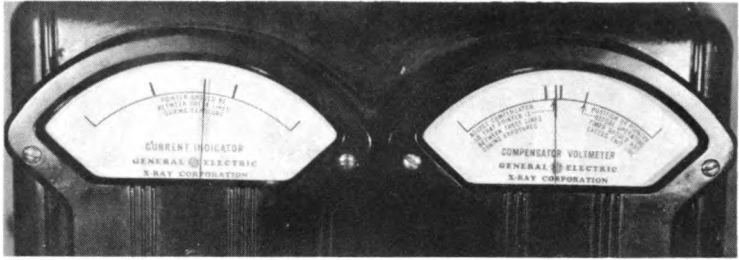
Current indicator and compensator voltmeter, while X-rays are being generated. Instrument panel during generation of X-rays.
